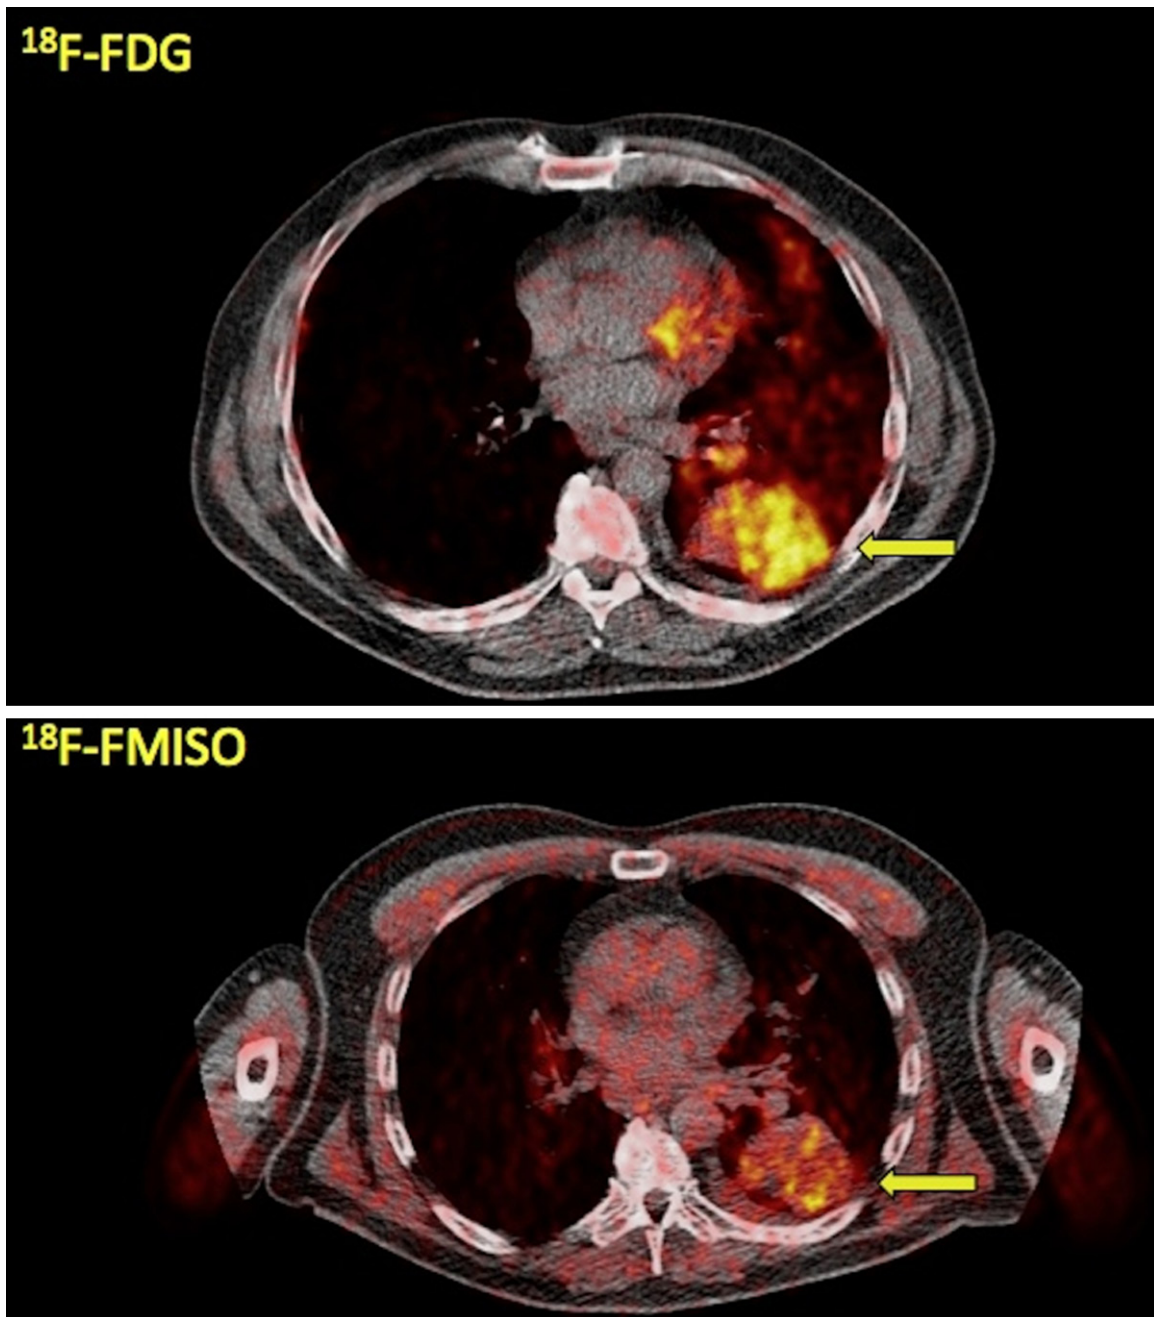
A 61-year-old patient with stage IIIB NSCLC of the left lung. Transaxial PET/CT images at the level of the lungs reveal the tumor in segment 6 of the left lung with enhanced tracer uptake both in ^{18}F -FDG PET/CT (arrow, upper row; $\text{SUV}_{\text{average}} = 8.6$, $\text{SUV}_{\text{max}} = 13.0$) as well as in ^{18}F -FMISO PET/CT (arrow, lower row; $\text{SUV}_{\text{average}} = 3.4$, $\text{SUV}_{\text{max}} = 5.0$).
